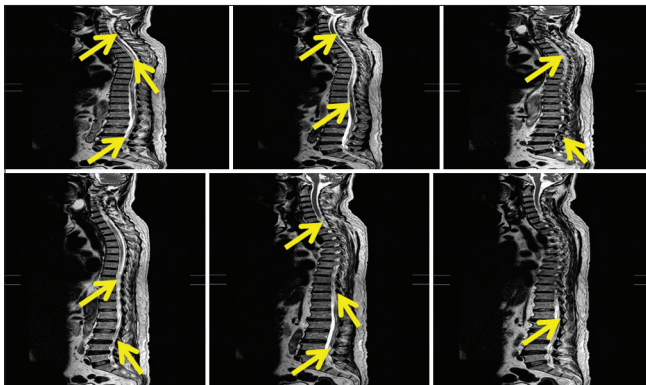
Magnetic resonance imaging whole spine with intravenous contrast patient acute transverse myelitis
